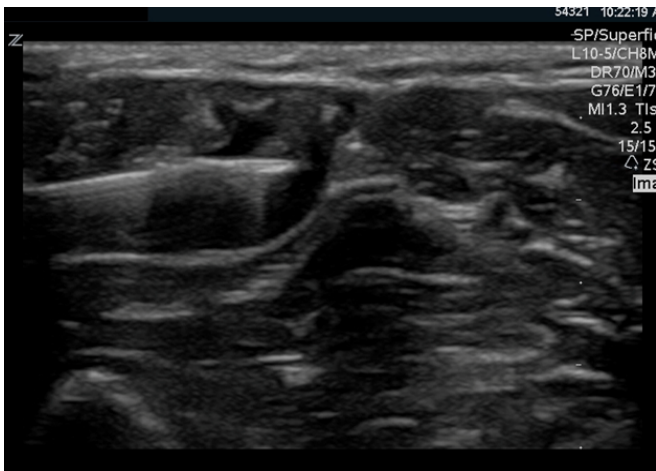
Ultrasound guided nerve block. Image demonstrates a needle being directed towards a triangular shaped nerve. Anesthetic solution is beginning to surround the nerve.
